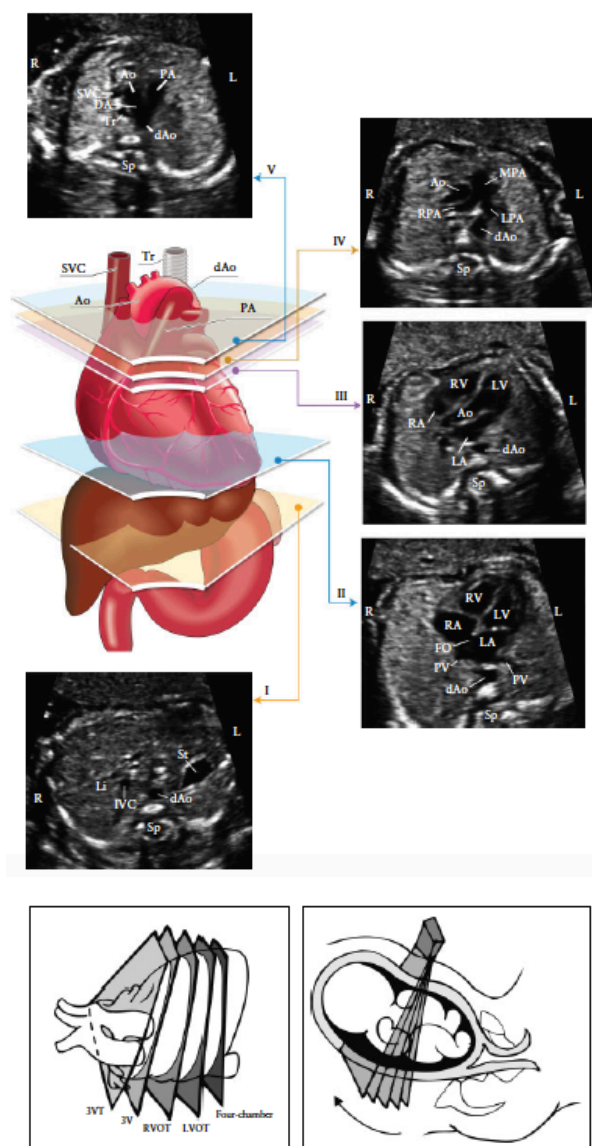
Main axis of fetal heart screening. I: most caudal plane, showing fetal stomach (St), descending aorta cross section (dAo), spine (Sp), and fetal liver (Li). II: four-chamber view of fetal heart, showing right and left ventricle (RV, LV), atria (RA, LA), foramen ovale (FO), and pulmonary veins beside descending aorta. III: left ventricular outflow tract view, showing aorta (Ao), LV, RV, LA, and RA with descending aorta cross section (dAo). IV: most cephalad position (right ventricular outflow tract view) showing pulmonary artery (MPA) and its branches (RPA dan LPA), ascending aorta (Ao), and descending aorta (dAo). V: three vessels tracheal view show superior vena cava (SVC), pulmonary artery (PA), ductus arteriosus (DA), aortic arch (Ao-dAo), and trachea (Tr). Cited from: The International Society of Ultrasound in Obstetrics, 2013.¹⁹
